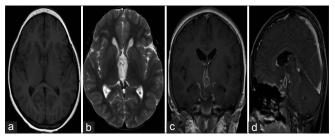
Preoperative magnetic resonance images. The lesion shows low signal intensity in T1-weighted axial images (a), high signal intensity in T2-weighted images (b), and intense enhancement after gadolinium administration on coronal (c) and sagittal (d) sections
